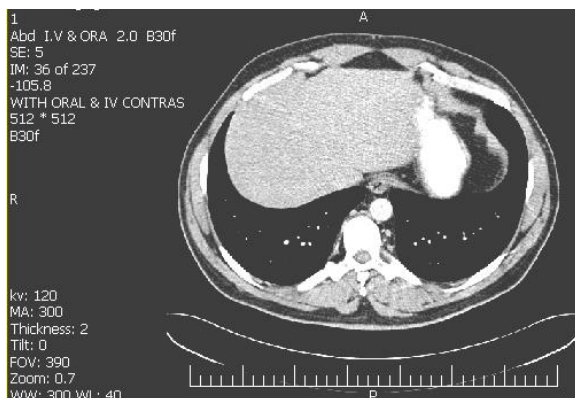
The image of abdominal tissue's slice by CT scanning from an X-Z view
